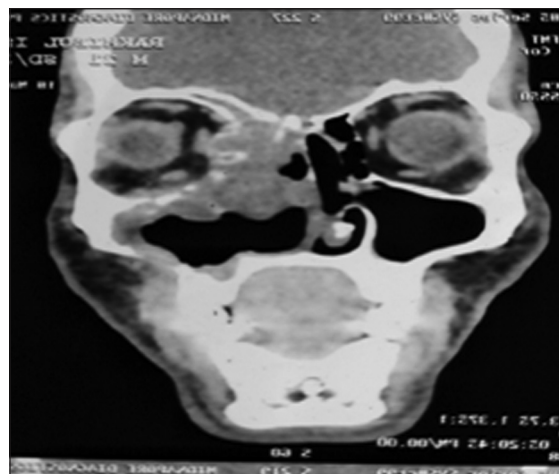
Contrast-enhanced computed tomography shows large enhancing left sinonasal mass extending posteriorly to nasopharynx, laterally to infratemporal fossa, and superiorly to upper limit of left orbit. Anteriorly, the lesion also extends to subcutaneous plane. Extensive bone erosion is seen. Bilateral neck node levels IB, II, and V lymph nodes are also enlarged
